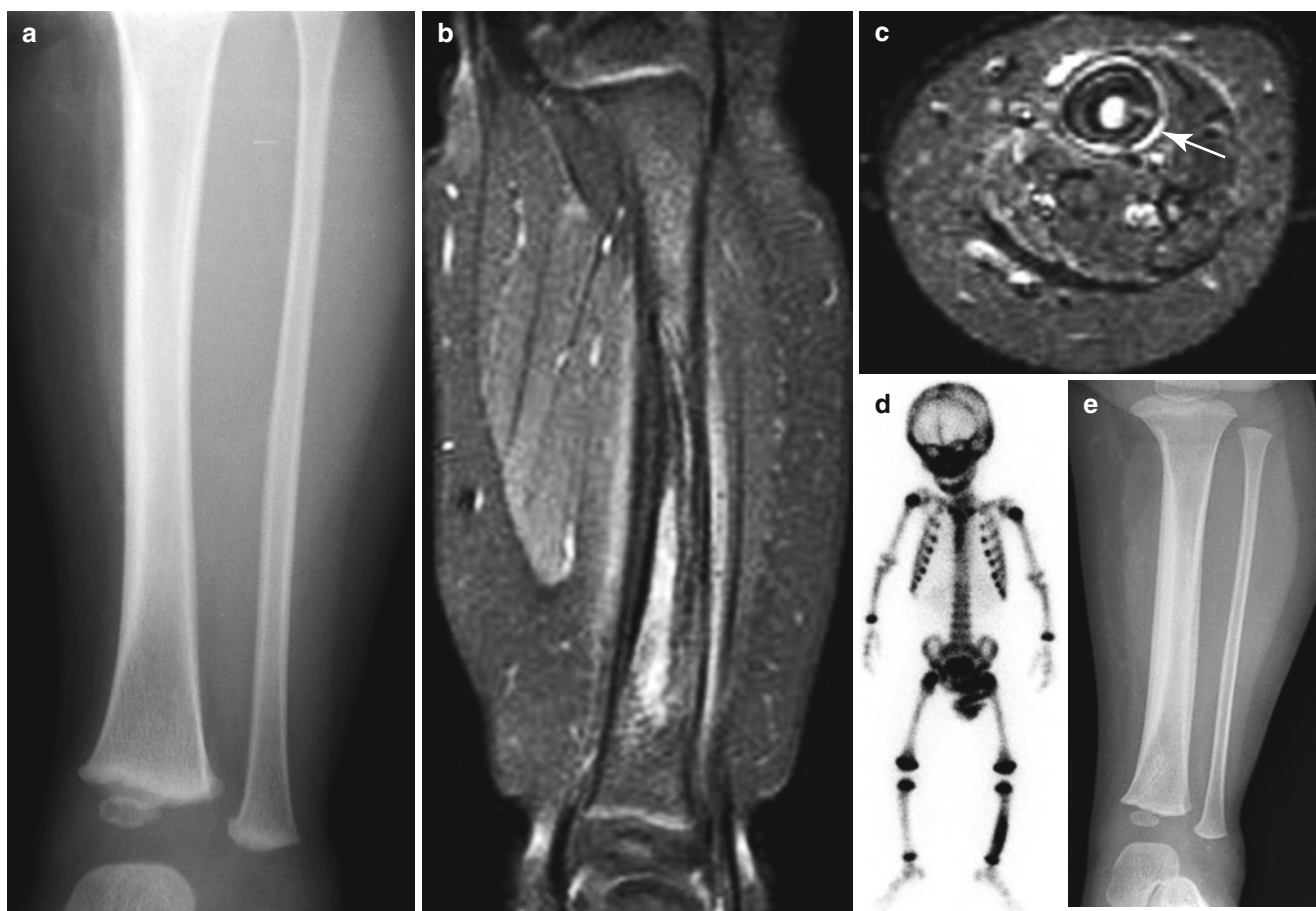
Toddler's fracture in a 2-year-old boy presented with limping gait. (a) Initial radiograph of left lower leg shows no bony abnormalities. (b, c) Fat-suppressed contrast-enhanced T1-weighted sagittal (b) and axial (c) MR images show fracture line (arrow in c) with surrounding marrow edema and periosteal reaction. (d) Bone scan shows increased uptake in the left tibia shaft. (e) Follow-up radiograph after 2 weeks reveals cortical thickening with periosteal reaction of the tibia (Courtesy of Dr. Lee HJ, Keimyung University School of Medicine)
